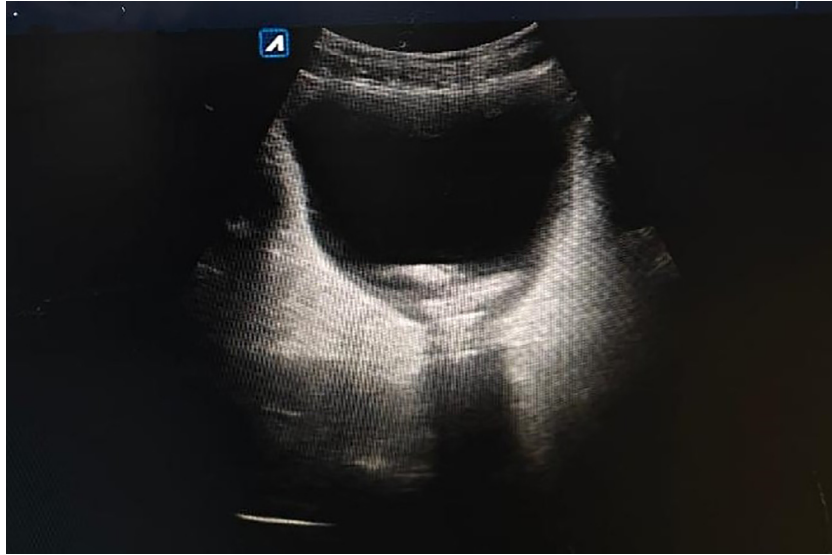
Ultrasound of the urinary bladder demonstrates coiled distal segment of DJ stent.
